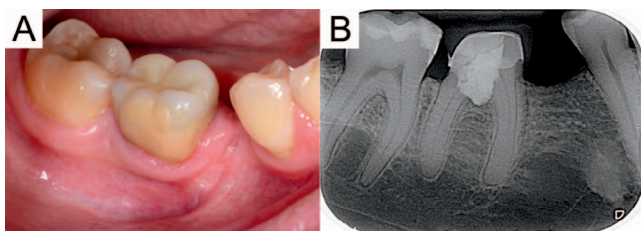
Eight-year clinical (A) and radiographic (B) appearance of tooth 30 after the multidisciplinary treatment.
